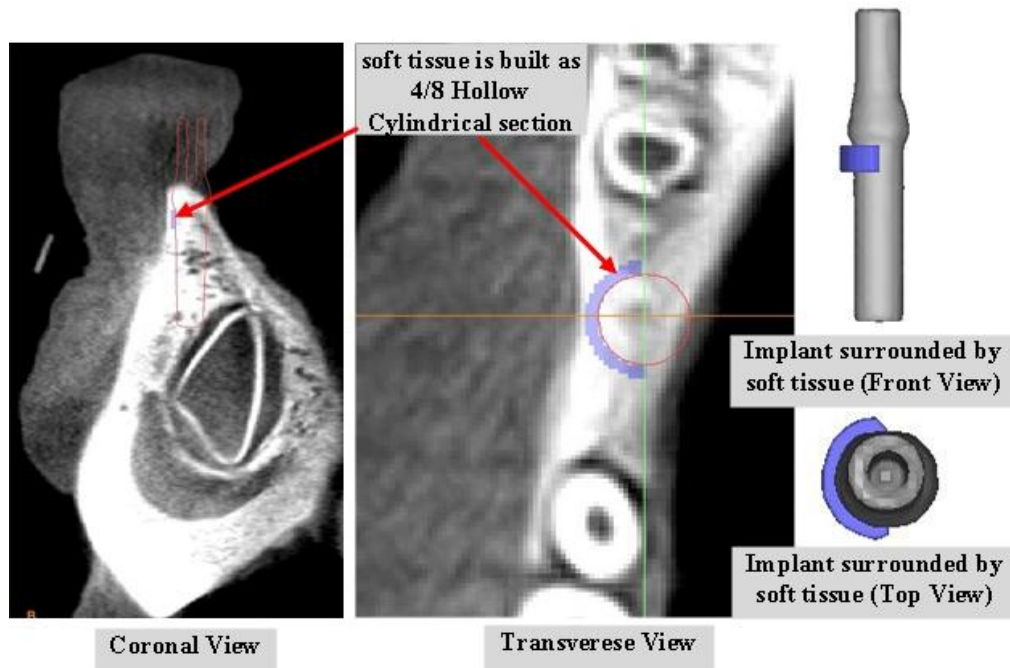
Transverse and coronal views of a slice of CT image showing the soft tissue as 4/8 and 6/8 hollow cylindrical section surrounding the implant, and the 3D models of both implant and soft tissues
